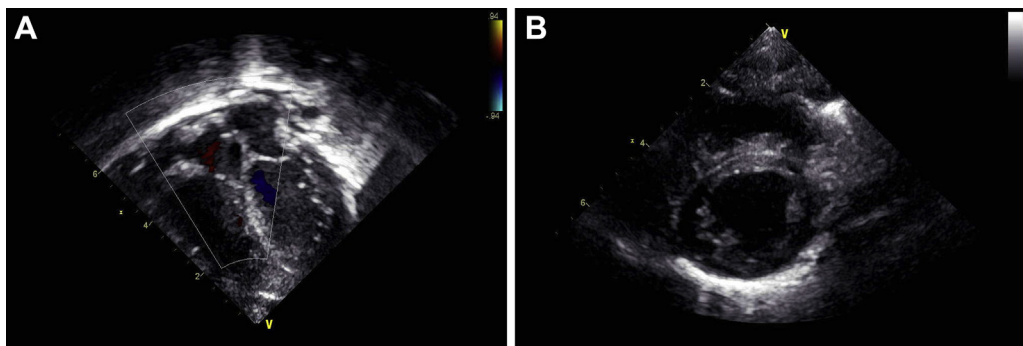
(A) Transthoracic apical four-chamber view (with color Doppler overlay) of the left and right ventricles and normal interventricular septum with resolution of the septal hematoma mass. (B) Transthoracic parasternal short-axis view of the left and right ventricles, normal interventricular septum, and resolved septal hematoma.
